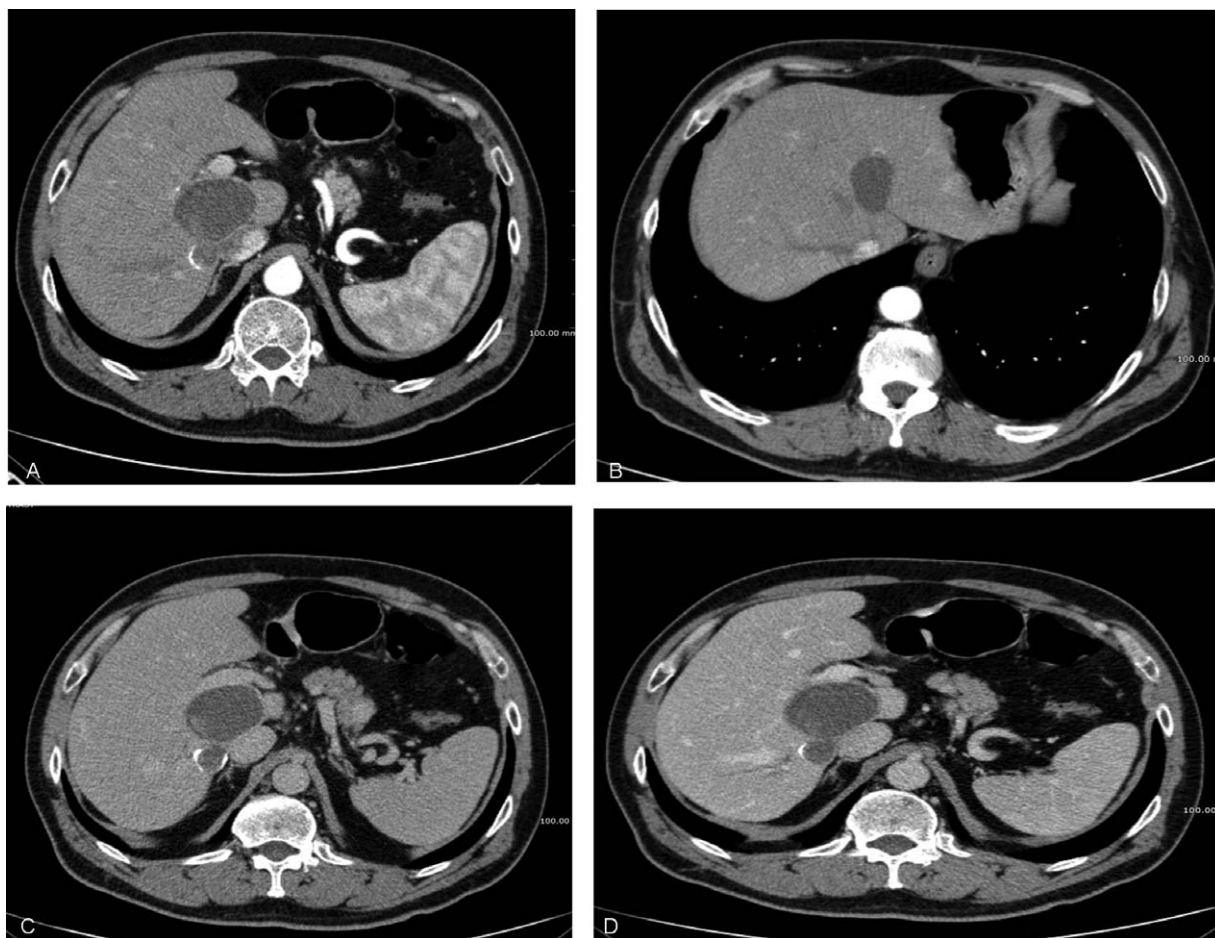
CT scan of a 68-year-old man with two hydatid cysts in close vicinity to the inferior vena cava. (A–D) A cysto-biliary communication was also present. Subtotal pericystectomy along with cholecystectomy and T-tube placement was performed.
